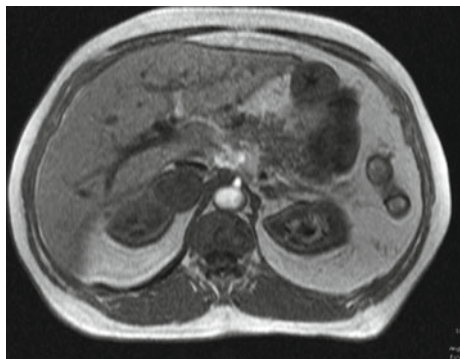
MRI shows a right, 4 cm well defined adrenal mass. In this case MRI was indicated for gastro-intestinal disease and documented (incidentally) the adrenal tumor
